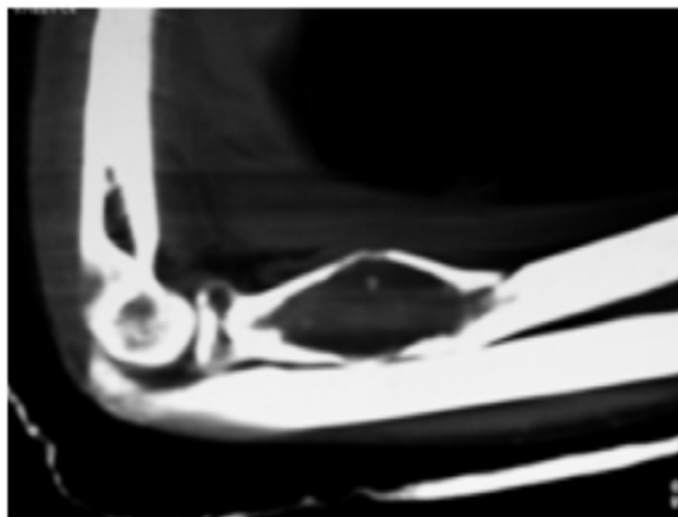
2 CT scan of Elbow showing expansile lytic lesion with fracture of proximal radius
